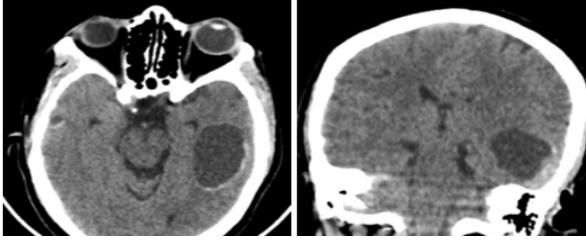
CEREBRAL HYDATID (A)axial (B)coronal reconstructed CT image showing well defined cystic lesion occupying left temporal lobe in a 55 year old female who is a known case of multifocal hydatids, who presented with seizures, which on intraop proved to be a HYDATID cyst.
